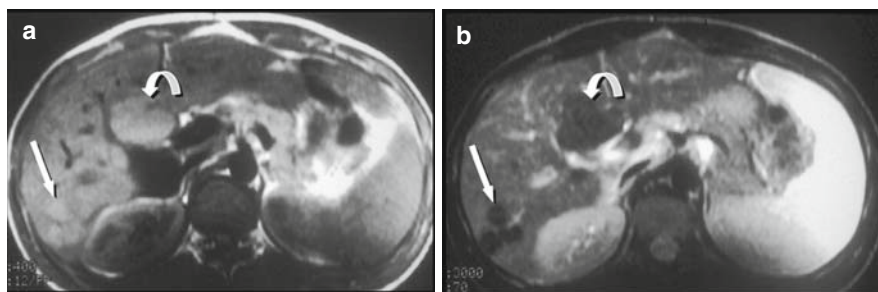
Dysplastic nodule. (a) T1-weighted MR demonstrates 2.0 cm (arrow) and 3.0 cm nodules (curved arrow) that are slightly hyperintense to surrounding liver. (b) T2-weighted MR shows the same lesions are slightly hypointense to liver.
